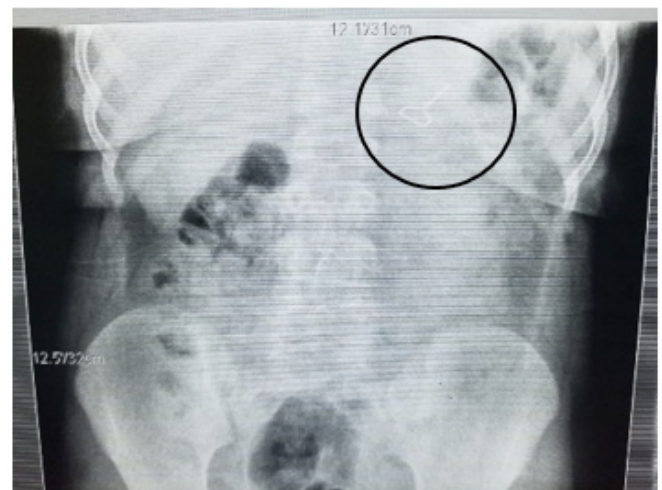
Frontal X-Ray, presence of the key device.
